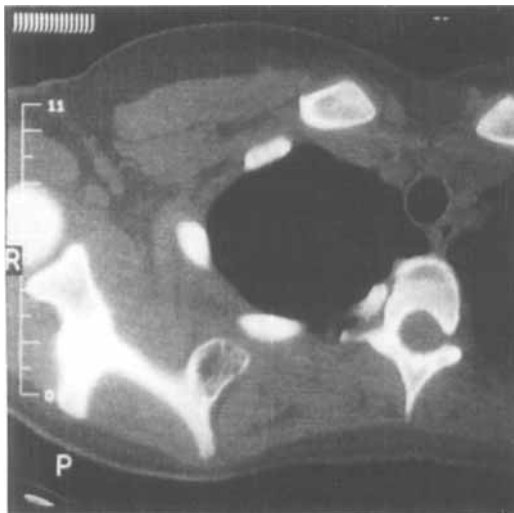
CT scan of the osteochondroma.
